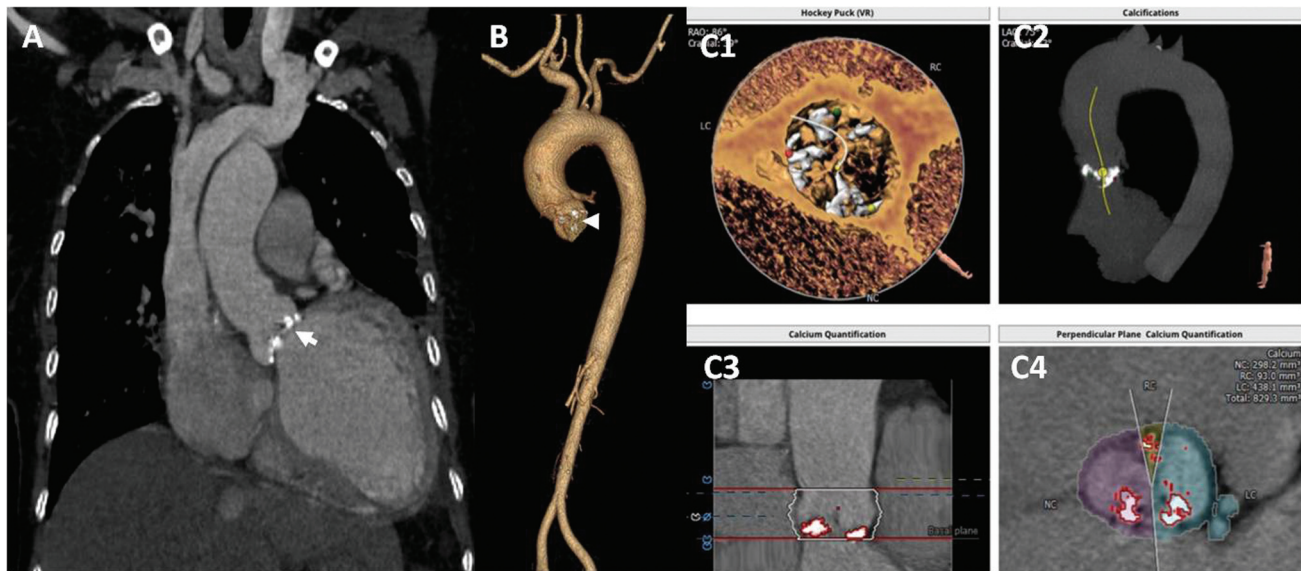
Coronal section computed tomography angiogram and volume rendering image of aorta showing severe aortic valve calcifications (small arrow in A and arrowhead in B). Quantifications of aortic valve calcifications (C1–C4).
